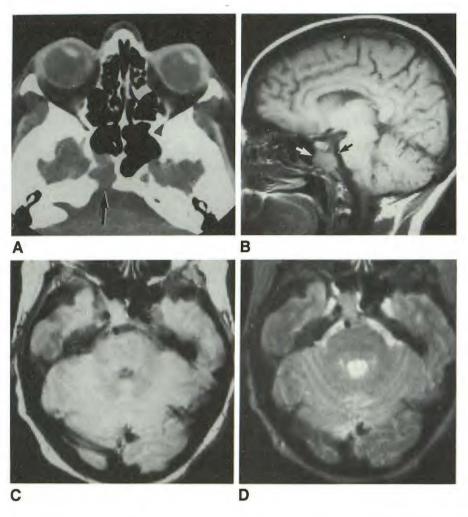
A, Unenhanced cranial CT scan shows mass in posterior aspect of right sphenoid sinus, with clear destruction of clivus (arrow).
